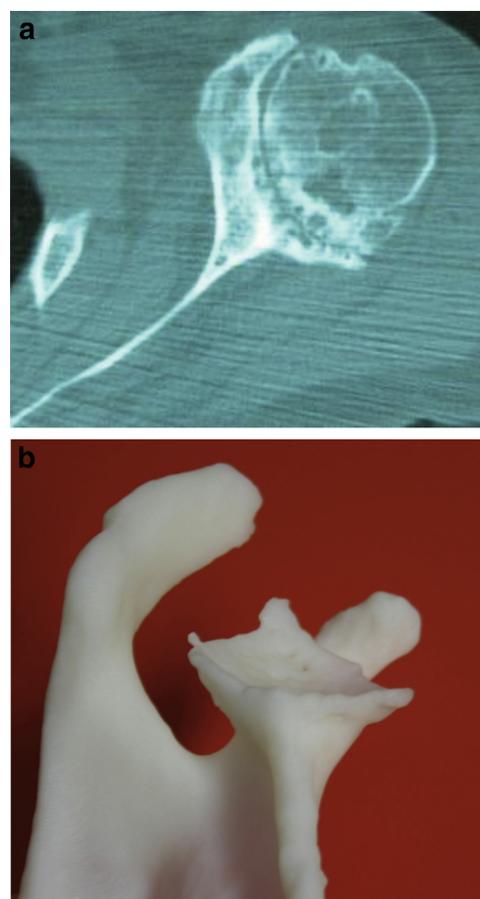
(a) Computed tomography scan and (b) stereolithographic model from 2 separate patients in this series.
